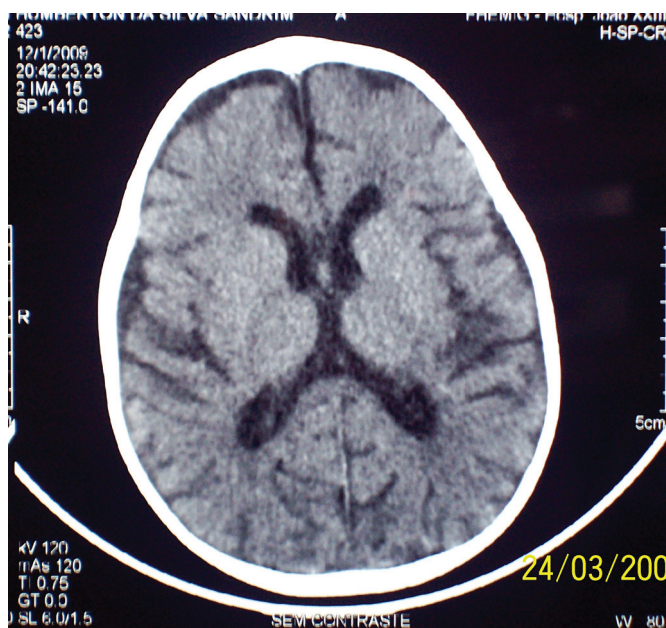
Computed tomography scan of the brain showing diffuse reduction of brain volume.
